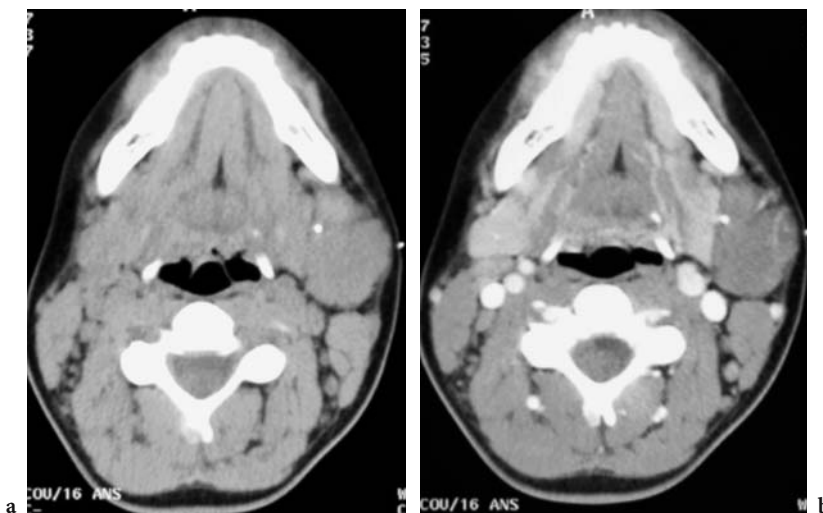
a Axial unenhanced cervical CT of a 16-year-old female shows a slightly hypodense mass containing a calcified phlebolith in the left parotid region. b After contrast injection, the venous malformation slightly enhances, remains hypodense and is better delineated
